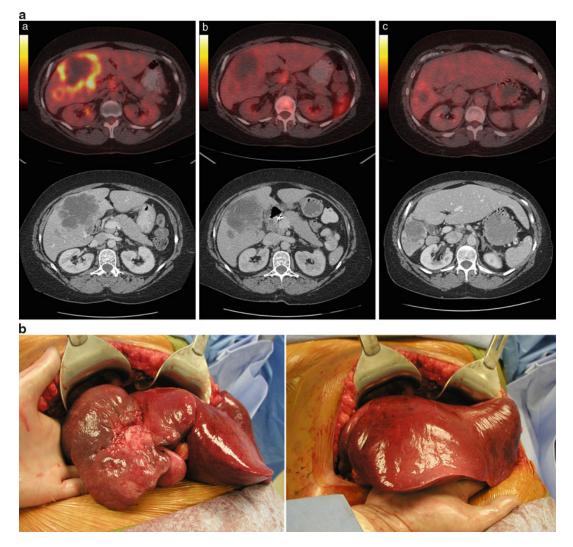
(a) FDG-PET/CT image sets demonstrating progressive decrease in the functional and anatomic volume of the tumor with concurrent left lobe hypertrophy. *a*: pretreatment, *b*: 4 weeks after first SIRT treatment, *c*: at
